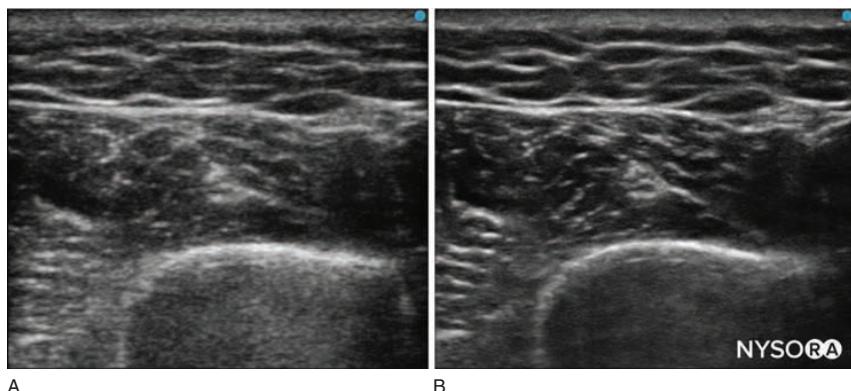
Ultrasound image of the radial nerve at the elbow with (A) conventional and (B) compound imaging.
